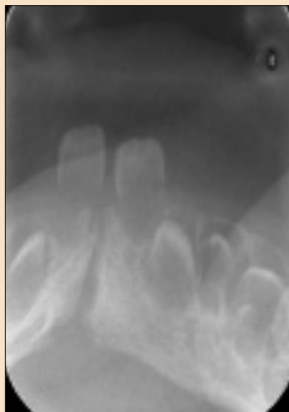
Mandibular anterior occlusal radiograph taken at age 17 days. Neonatal teeth 71 and 81 are present.
